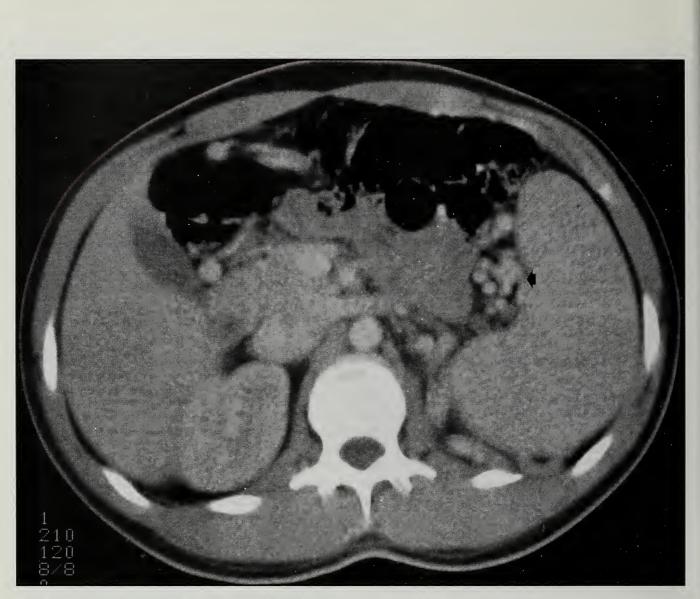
Computed tomographic scan documenting large and extensive splenic perihilar varices.
